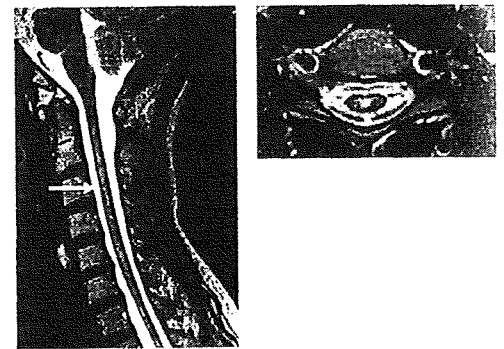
Longitudinally extensive spinal cord lesion (LESL) in a case of NMO. T2-weighted cervical MRI demonstrates an extension of T2 high density involving central gray matter, which is characteristic of LESL associated with NMO.
